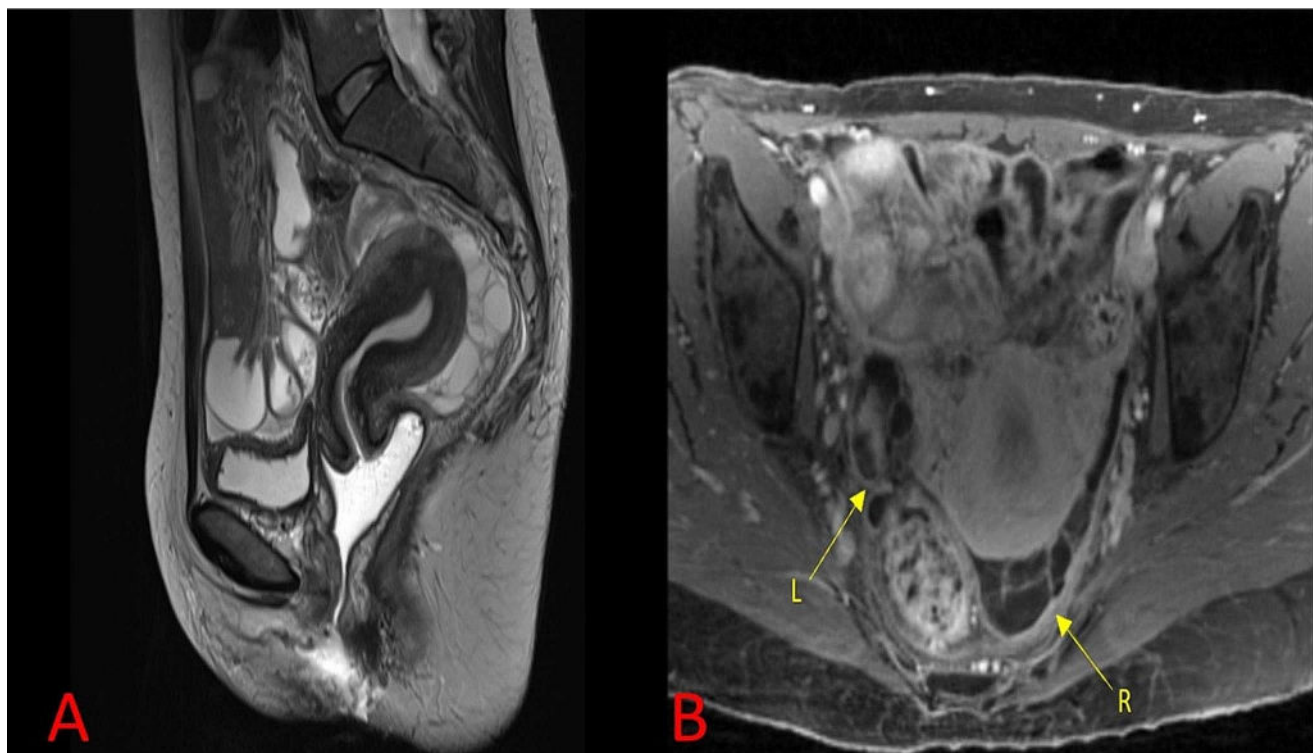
MRI findings. MRI: magnetic resonance imaging. R: right adnexa L: left adnexa. A: Mild thickening along the posterior uterine body and pelvic ligaments (T2 signal sequence). B: Cystic mass in the right adnexa (T1 signal sequence)
